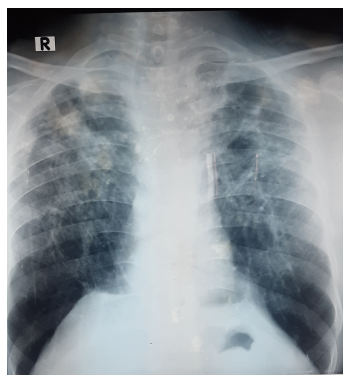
Chest X-ray showed profuse, multifocal, poorly defined consolidations predominantly localized in the upper, middle lung lobes, and a ground-glass appearance was observed in the lower lobes, concomitant with tracheal deviation towards the right.
